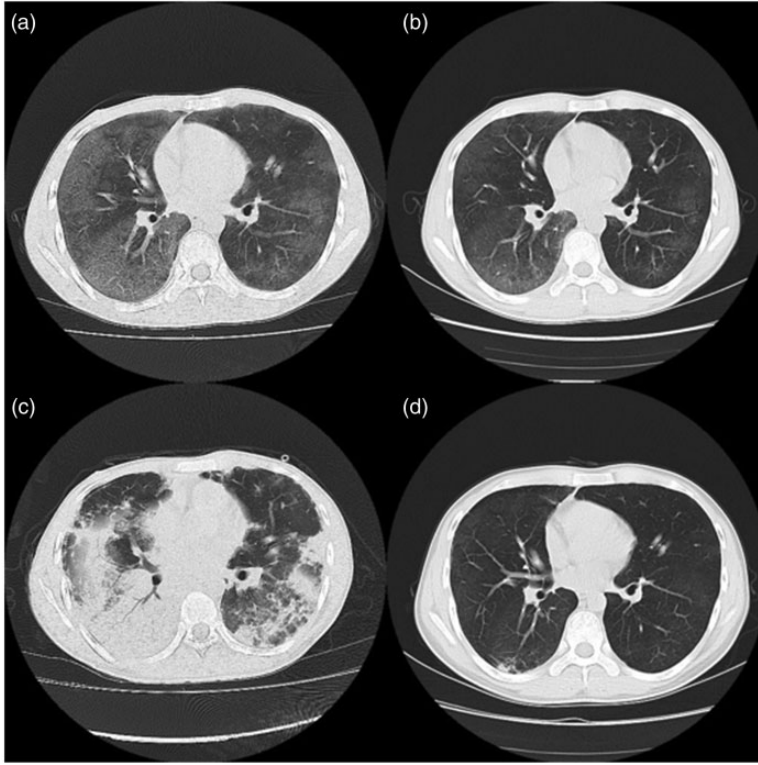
Chest CT findings. (a) Chest CT at first admission showed characteristic GGOs in the bilateral lungs. (b) A repeated CT performed after 21 days of TMP/SMX treatment demonstrated that the GGO in bilateral lungs were obviously resolved. (c) Chest CT at second admission showed deterioration of pulmonary infiltration mostly in the right lung. (d) Follow-up CT after 28 days of methylprednisolone and TMP/SMX treatment showed resolution of the GGOs and consolidation. CT, computed tomography; GGOs, ground-glass opacities; TMP/SMX, trimethoprim/sulfamethoxazole.
